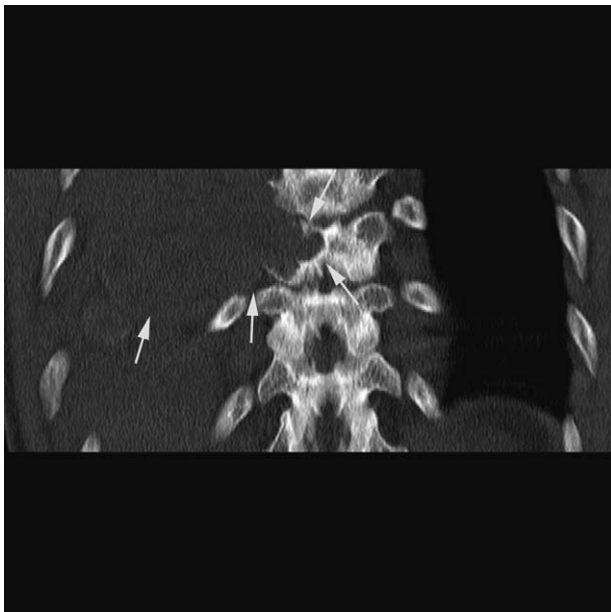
Computed tomography (CT) scan shows an osteolytic, expansive, and eccentric lesion on the vertebral and accessories (arrow heads). The lesion density is nonuniform.
